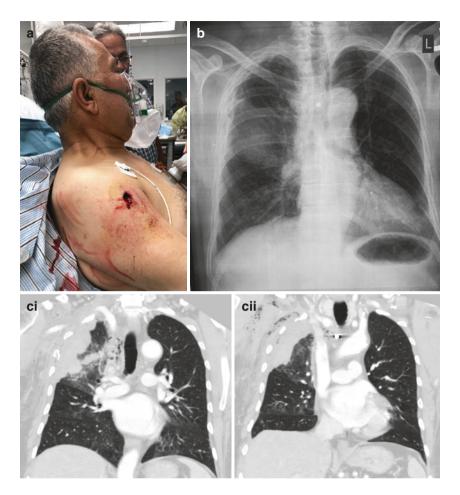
(a) Fragment wound to right lateral shoulder from suicide bomb attack. (b) Chest X-ray demonstrates a small fragment in the central chest. (c) CT scan shows the fragment trajectory through the right axilla and right upper lobe into the mediastinum and lodged immediately anterior to the trachea with small pseudoaneurysm of the right upper lobe pulmonary artery. He was evaluated with bronchoscopy and clinical observation and did not require further intervention
